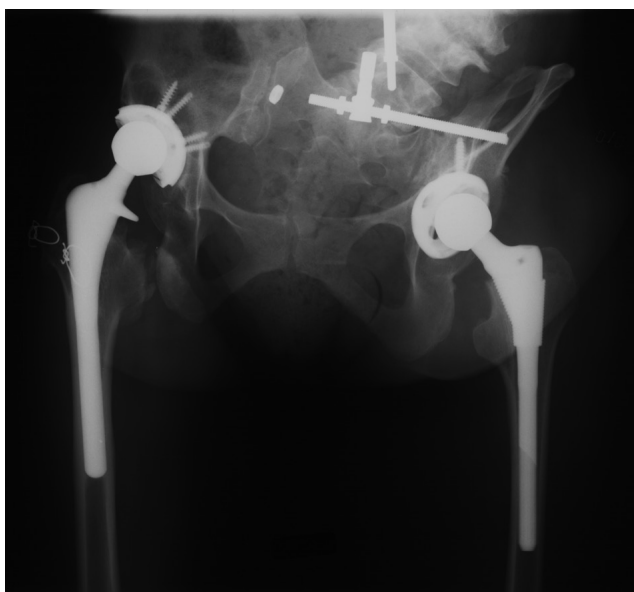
Anteroposterior pelvis radiograph after revision of loosened acetabulum. Cup abduction angle, 64°. Note significant scoliosis and pelvic obliquity.
